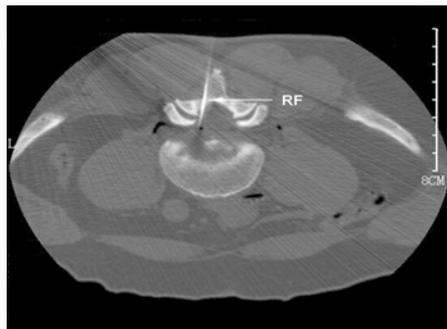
Intraoperative CT images of RF.
